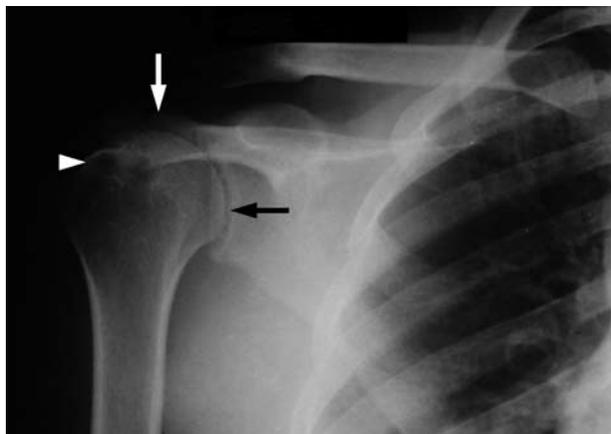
Radiograph at presentation shows relatively well-defined lytic area medial to greater tuberosity and extending into head of humerus (arrowhead), joint space maintained (black arrow) and mild superior subluxation of humeral head (white arrow).
